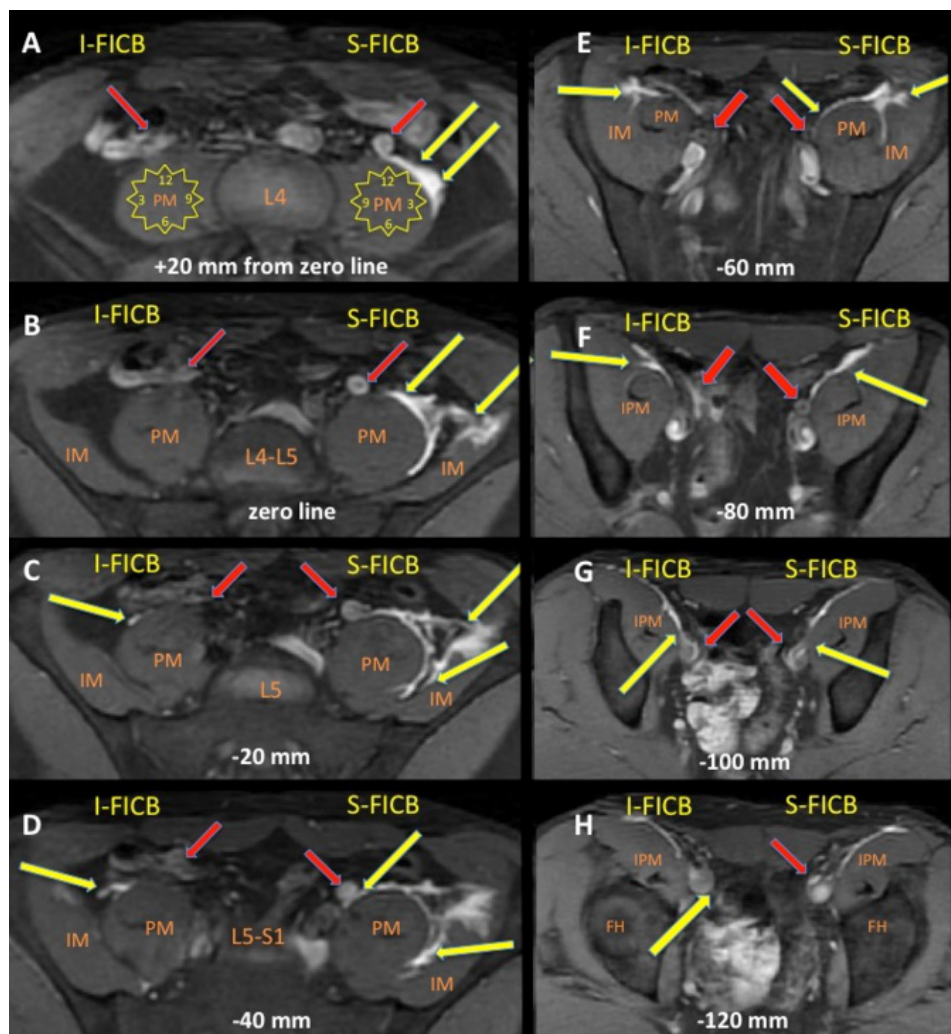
Spread of LA on axial MRI (T1 fat-sat) at different levels between A (+20 mm) to H (–100 mm) of the reference line (drawn between the two anterior superior iliac spines). FH, femoral head; I-FICB, infra-inguinal fascia iliaca compartment block; IM, Iliac muscle; IPM, iliopsoas muscle; LA, local anesthetics; PM, psoas muscle; S-FICB, supra-inguinal fascia iliaca compartment block. Yellow arrows indicate LA and red arrows indicate iliac artery.
